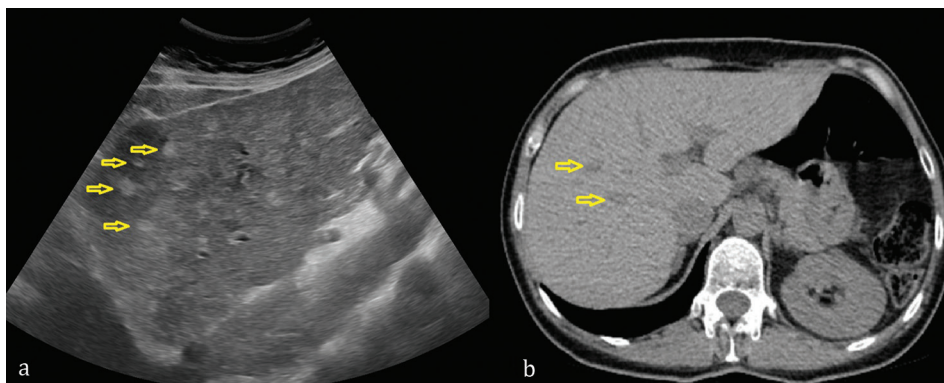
Liver Gaucheromas: a) ultrasound imaging: multiple hyperechoic lesions; b) MRI examination: no specific findings.
